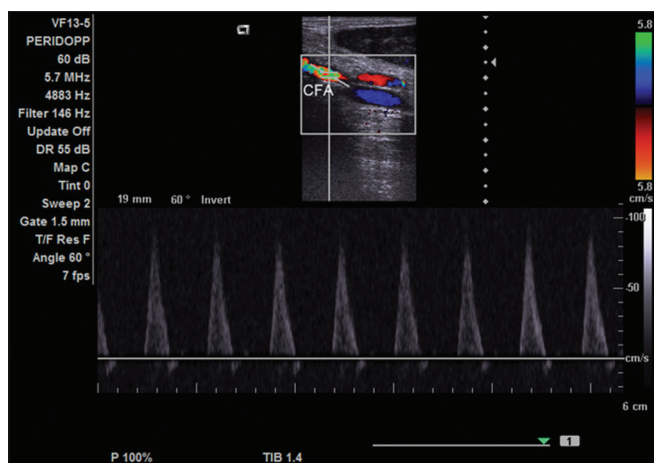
Longitudinal color Doppler image showing moderately stenotic common femoral artery with biphasic waveforms
